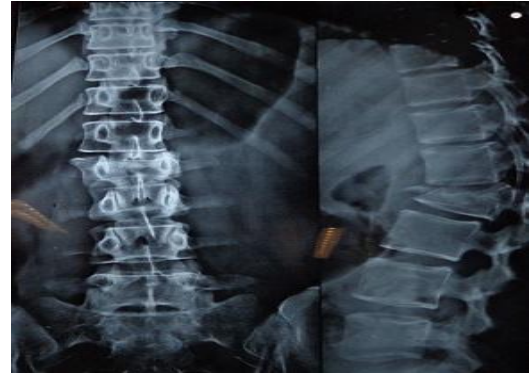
Pre-operative AP and Lateral x-ray showing wedge compression fracture of L2 vertebra.
